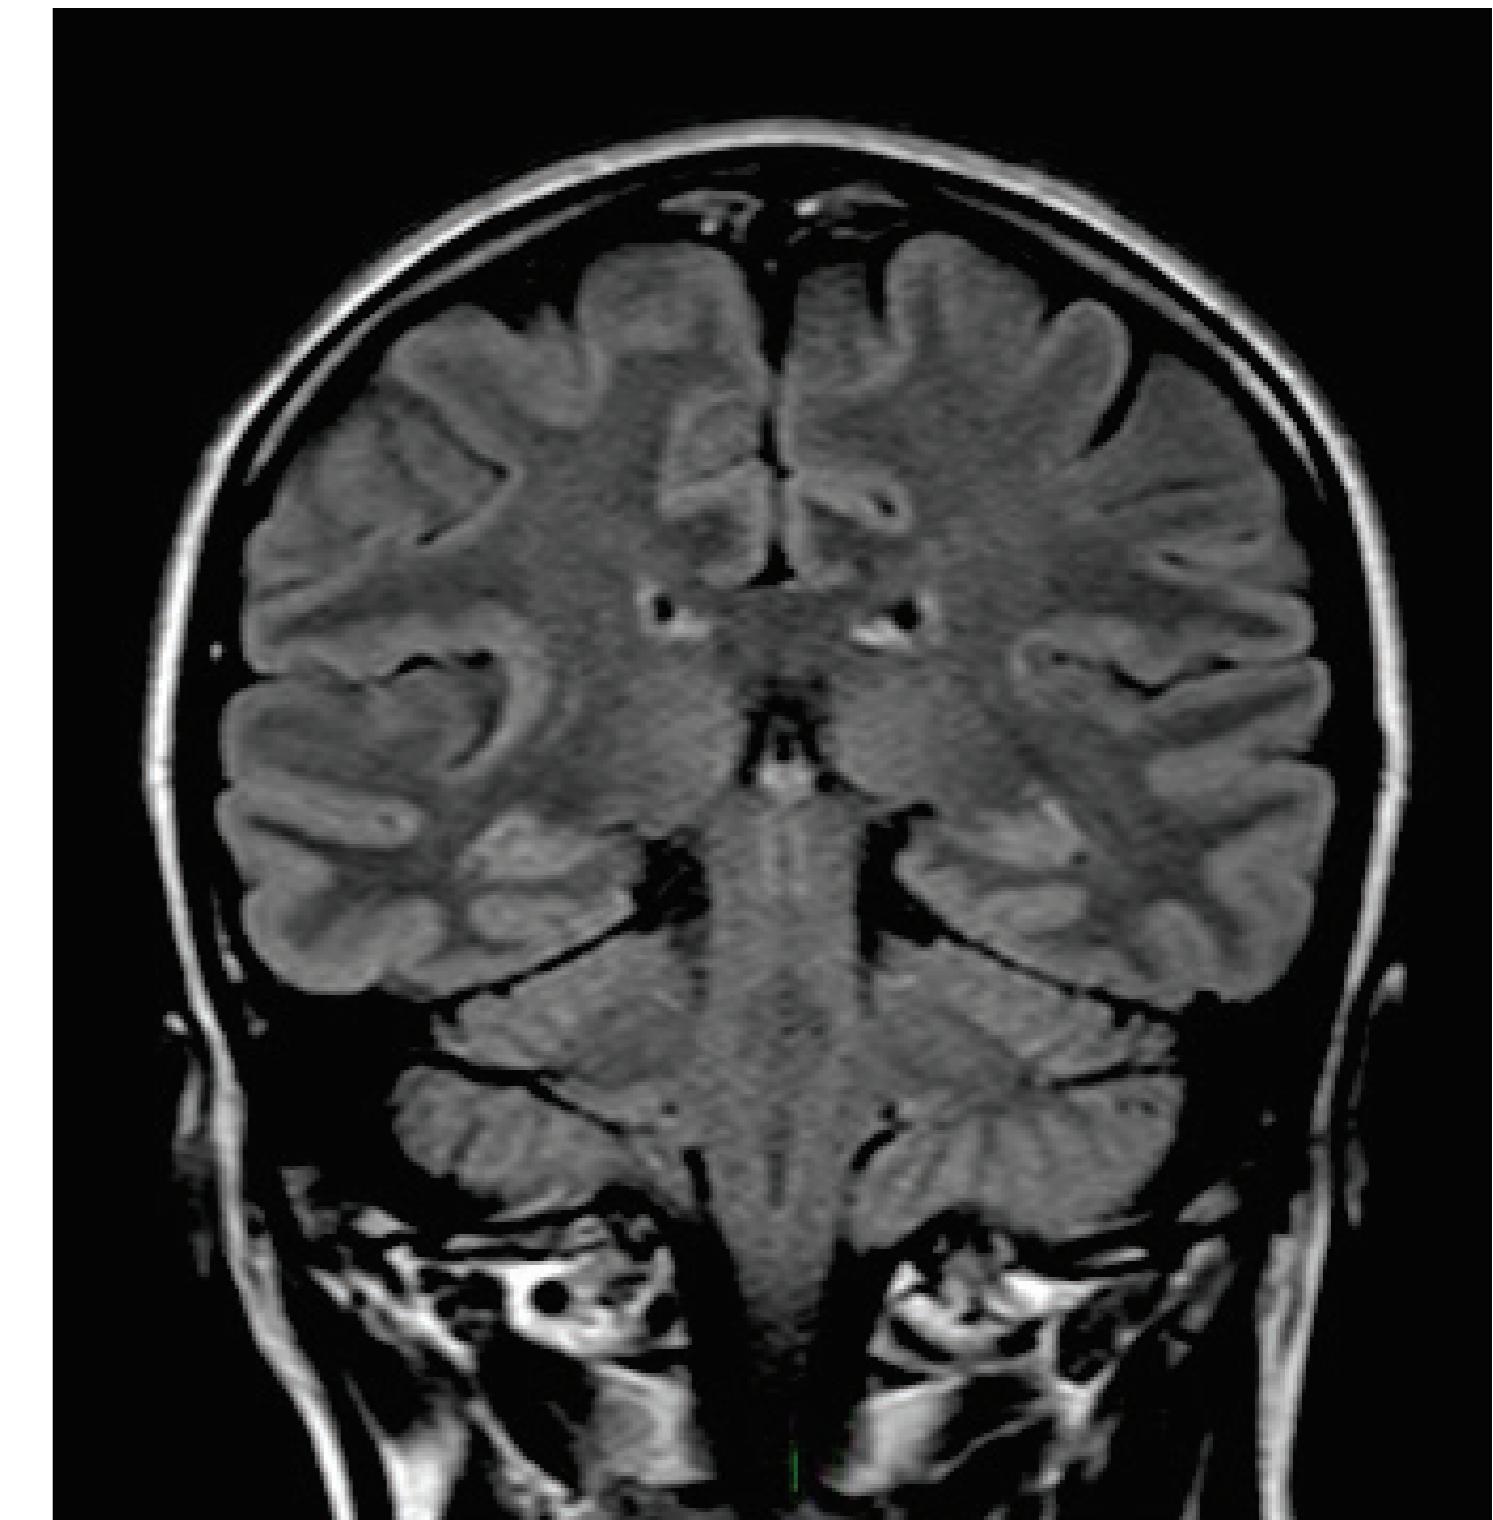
Follow-up MRI scan (FLAIR sequence, 09/2015), without evidence of the previous lesion.
